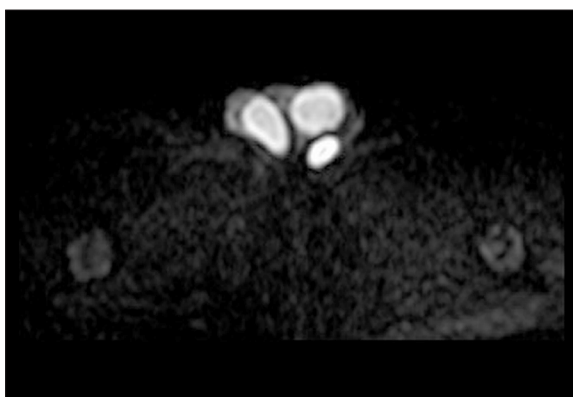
40-year-old man with polyorchidism. The axial diffusion weighted magnetic resonance image of the extra testis posteriorly to the left testis. The diffusion restriction pattern of the extra testis is similar with normal testis parenchyma.
